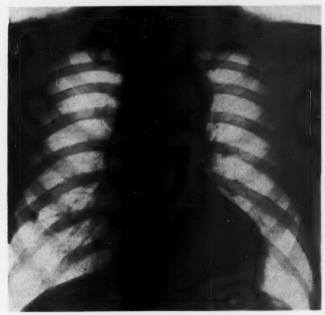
Chest x-ray, 1953.
